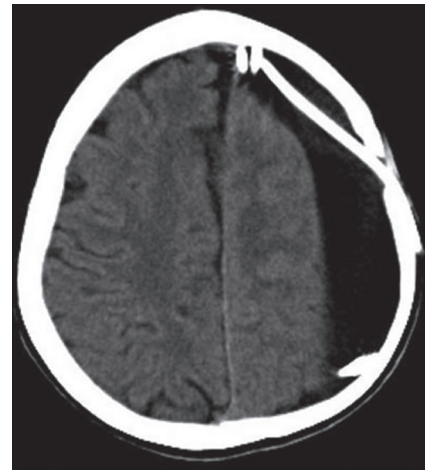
Control brain computed tomography scan showing that the shunt material completely migrated into the cranium
